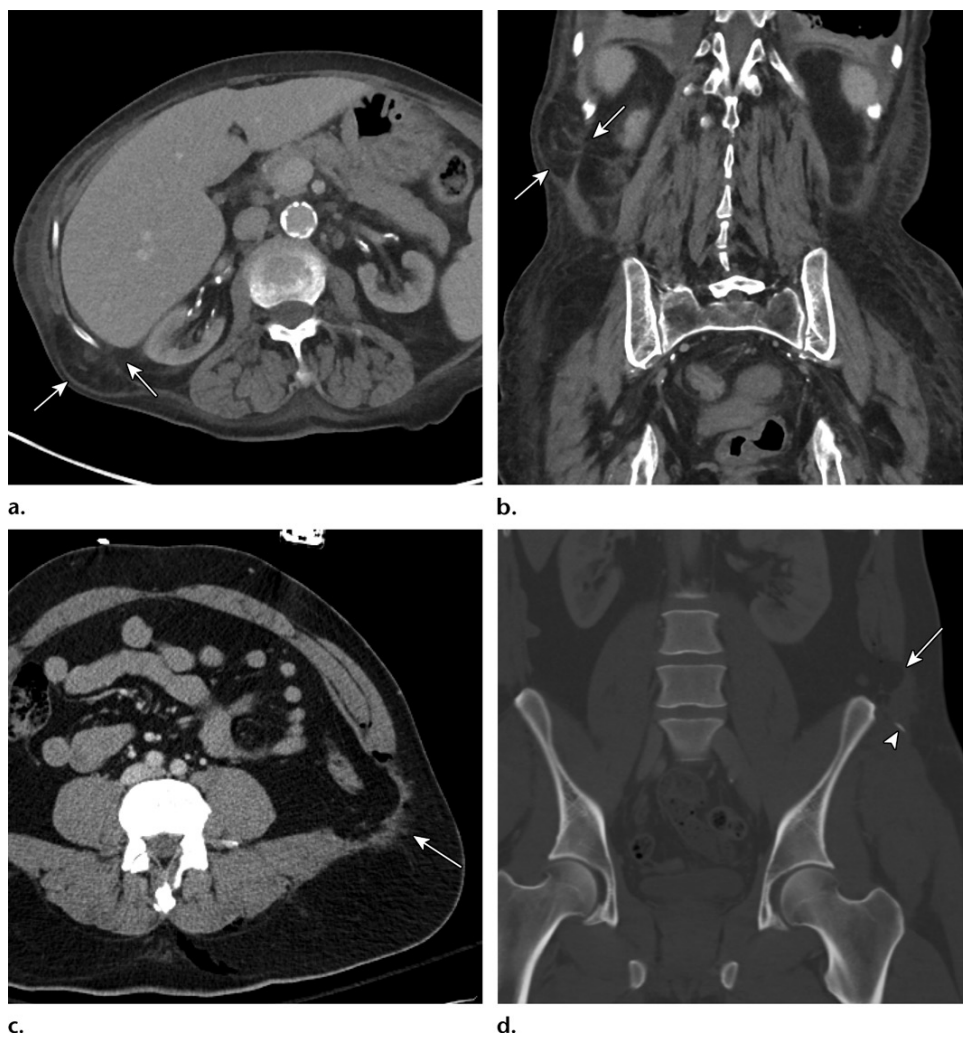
Lumbar triangle hernias in two different patients. (a, b) Axial (a) and coronal (b) CT images show a superior lumbar triangle hernia (arrows) in a 55-year-old man. (c, d) Axial (c) and coronal (d) CT images show an inferior lumbar triangle hernia (arrow) in a 39-year-old man. Note the associated small avulsion injury to the anterior superior iliac spine (arrowhead on d).
